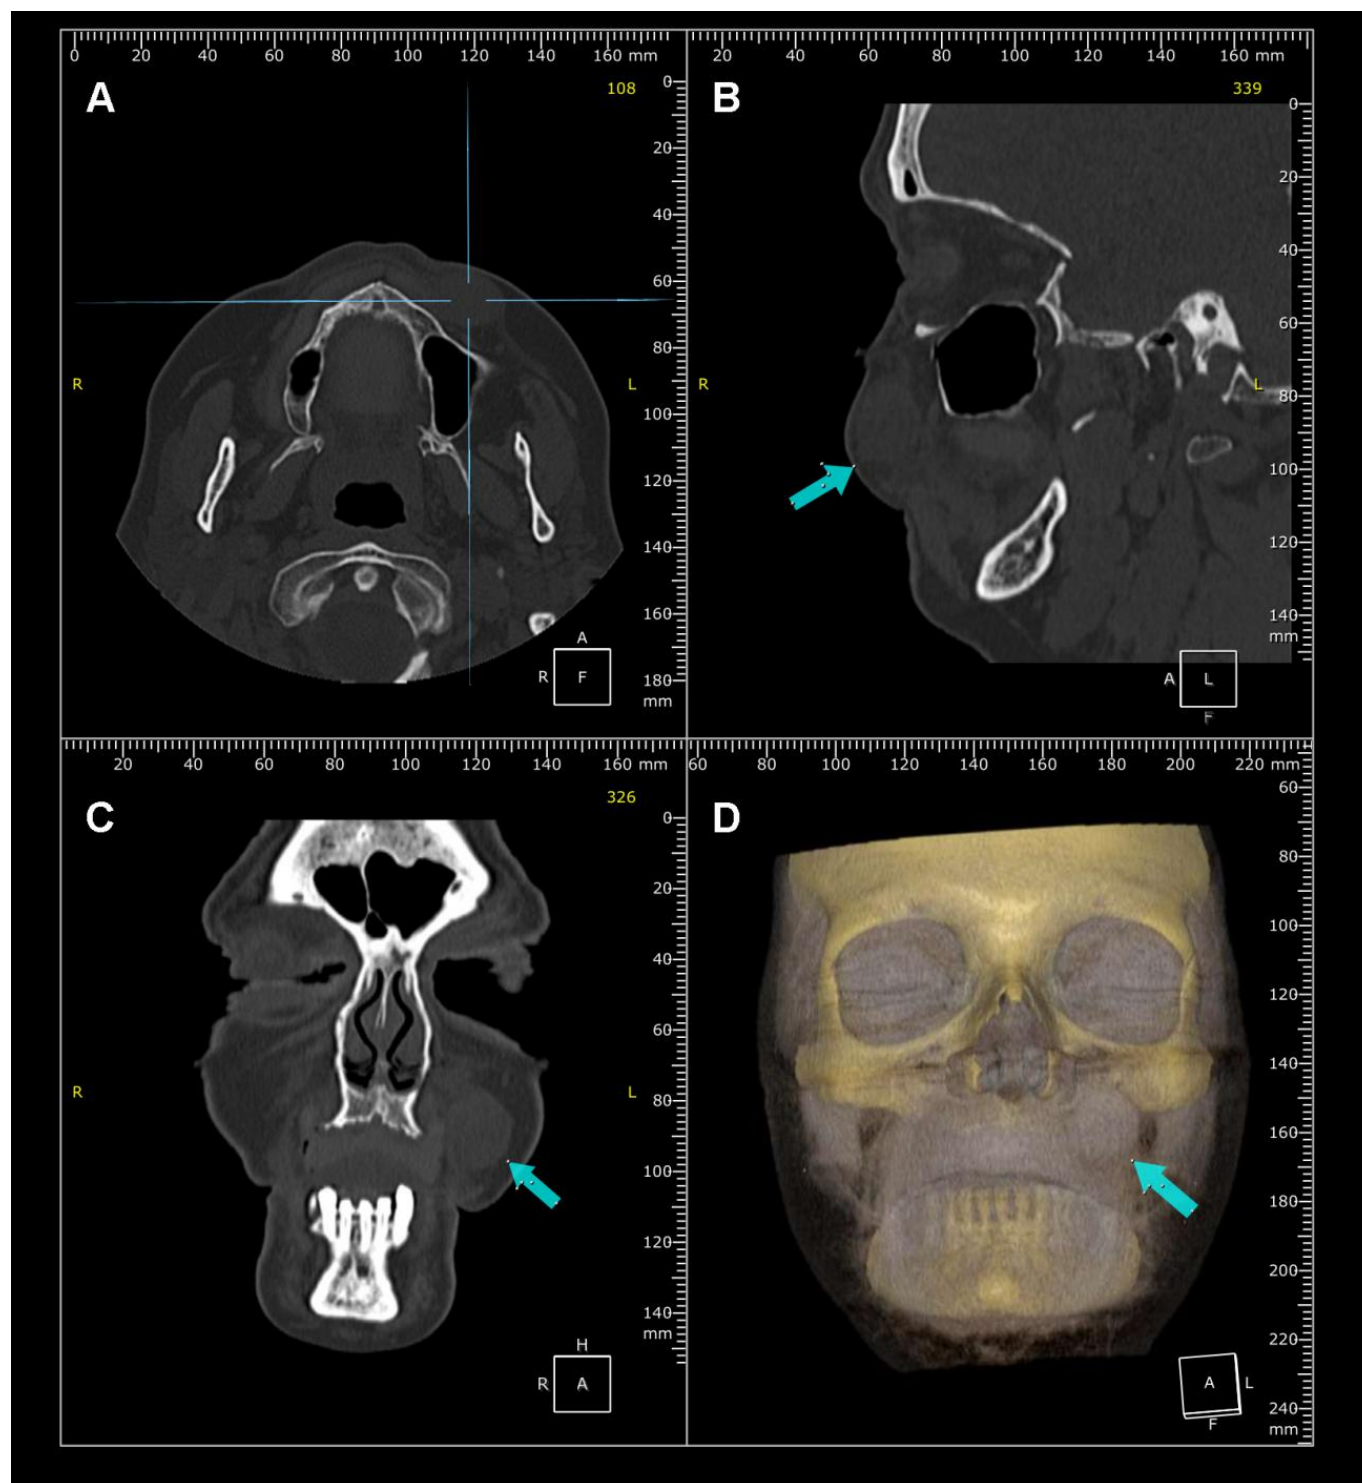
Imaging exams. (A) Conventional Computed Tomography demonstrating an isodense lesion relative to soft tissues, circumscribed, well-marginated, and with no evidence of adjacent structural involvement. Axial View. (B) Sagittal View. (C) Coronal View and (D) 3D reconstruction.
